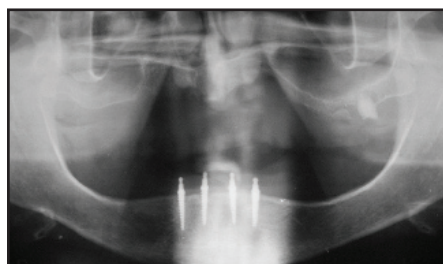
Panoramic radiograph at 24 months
